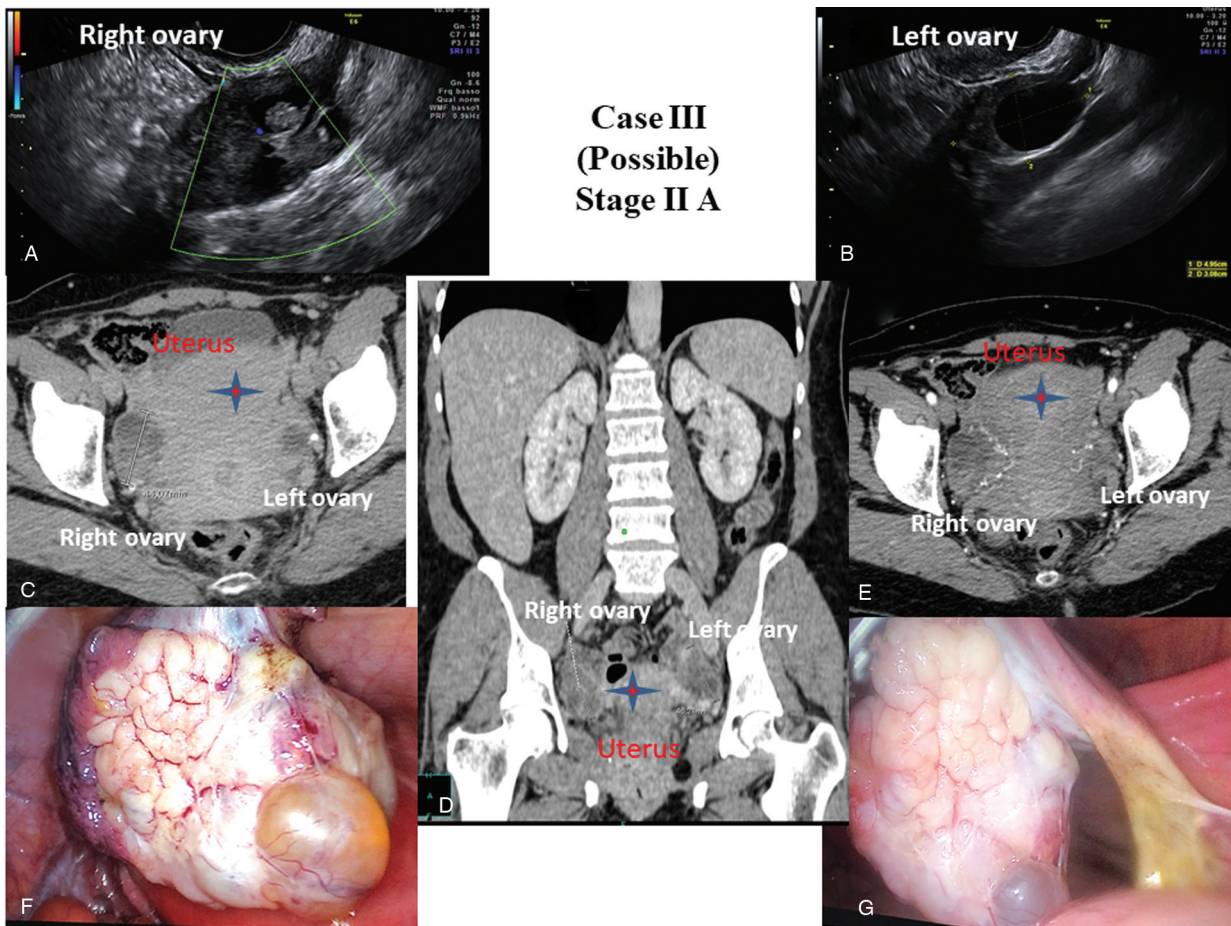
Case III (possible case): Stage II A. (A) TVUS right ovary, (B) TVUS left ovary, (C-E) CT images, laparoscopic findings of right (F) and left (G) ovary. TVUS, transvaginal ultrasound.
